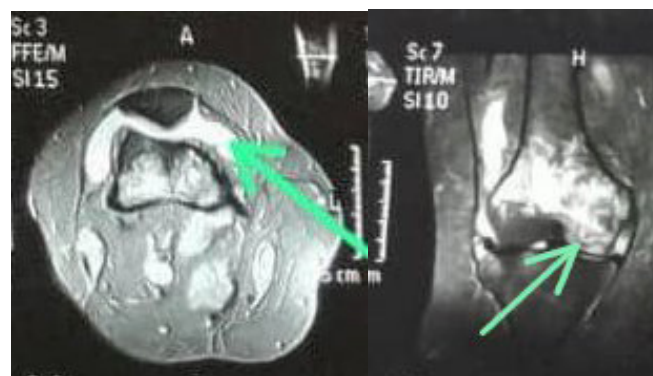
MRI of (left) the axial plane right knee joint showing joint effusion in T2W and (right) coronal plane of the right knee showing a serpiginous structure of low signal intensity in the medial femoral condyle representing a detached Echinococcus cyst membrane.
